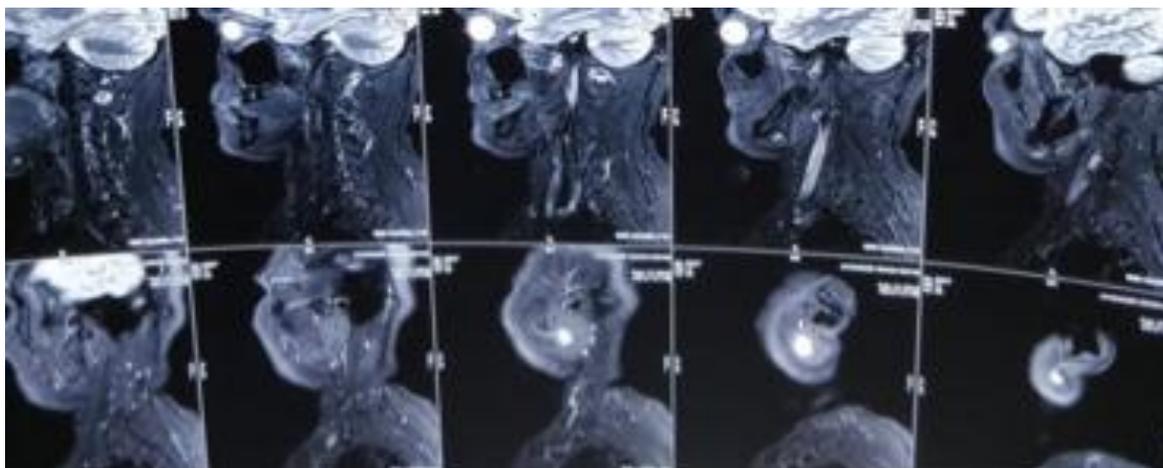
MRI face and neck, sagittal sections showing an oval altered intensity lesion in superficial lobe of parotid gland with no evidence of extension into the deep lobe.
